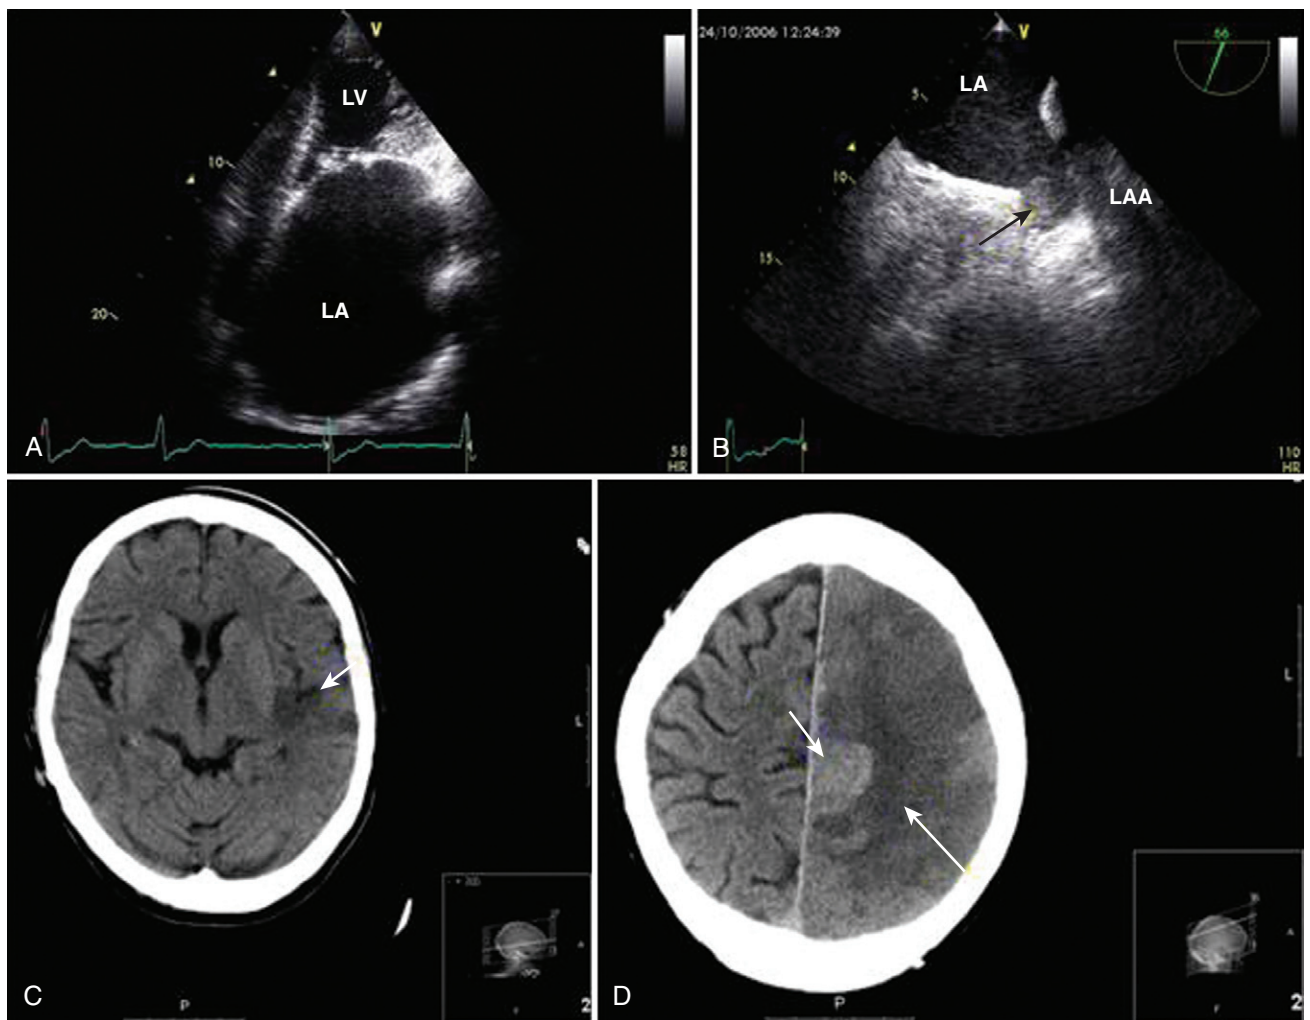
A, A gigantic left atrium in a patient with atrial fibrillation and mitral stenosis. B, Left atrial appendage thrombus (*arrow*) detected by transesophageal echocardiography in a patient with atrial fibrillation (AF). Note the presence of spontaneous echo contrast in the left atrium. C, A computed tomographic image of cerebral infarct (*arrow*) in a patient with AF but without neurologic symptoms (silent infarct). D, A computed tomographic image of acute ischemic stroke (*arrow*) with subsequent hemorrhagic transformation (*thick arrow*) in a patient with AF. LA, Left atrium; LAA, left atrial appendage; LV, left ventricle.
